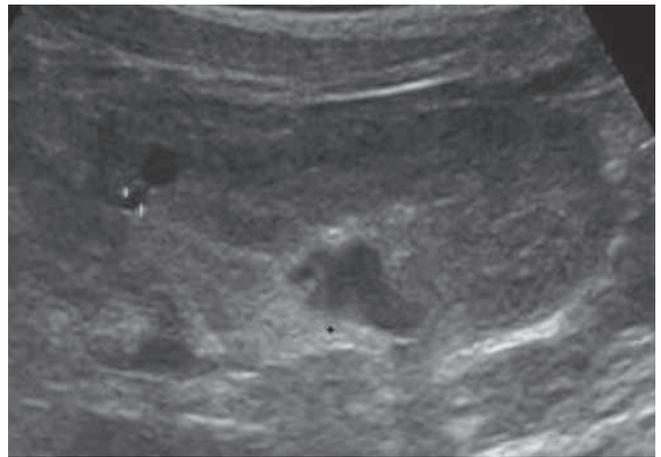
9-year old. Ultrasound scan in partial sagittal view shows two small cysts (arrows) in the cortex. No medullary cysts are found.
